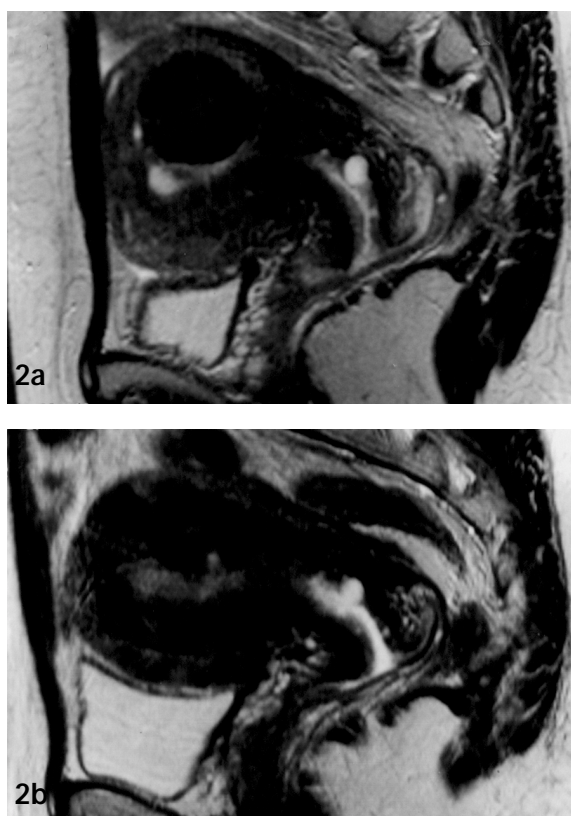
MR features of uterine fibroid before and after embolization. (a) T2-weighted sagittal image demonstrates a large mural fibroid before embolization. Incidental nabothian cysts are noted in cervix. (b) T2-weighted sagittal image 6 months after the embolization. The size of the fibroid has decreased.
